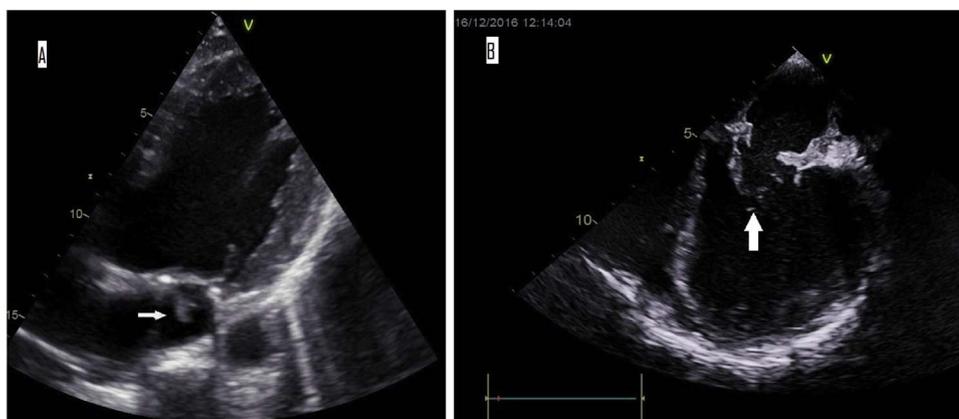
(A) Transthoracic echocardiography of a patient with *P. stutzeri* endocarditis, apical view of the left heart demonstrating a floating structure on the mitral ring, which is suggestive of a bacterial vegetation (arrow). (B) Transesophageal echocardiography of the same patient: long section of the mitral valve, demonstrating the same floating structure (arrow).
